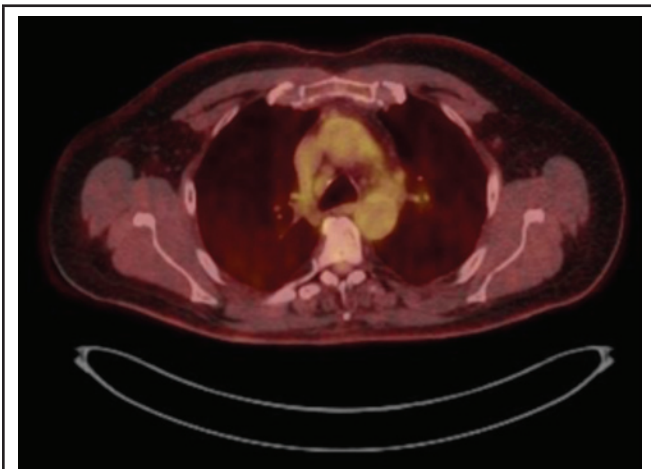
Fused PET CT, axial cut, showing 4R lymph node
